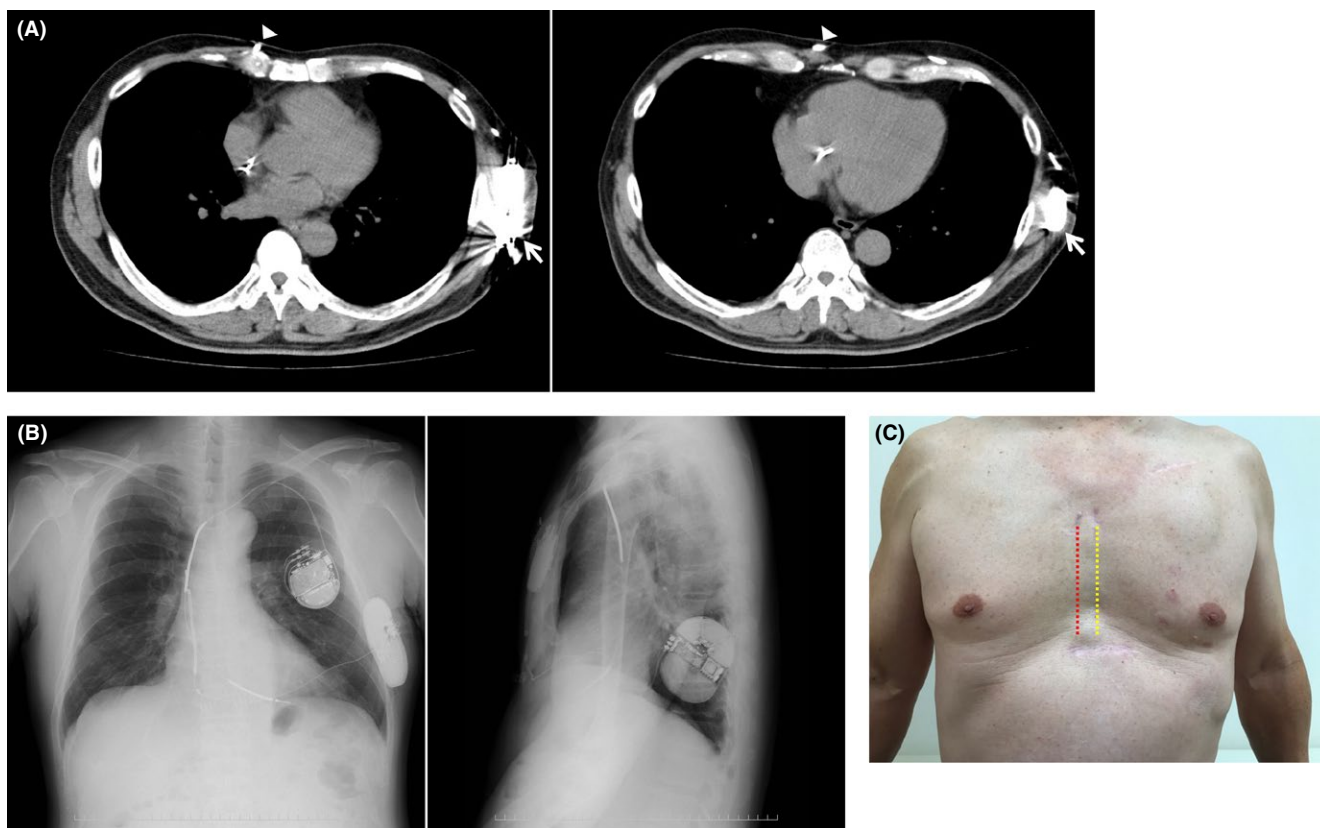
Images and operative scars after the subcutaneous implantable cardioverter defibrillator implantation. A, Computed tomography. Arrows indicate the generator inserted between the serratus anterior muscle and latissimus dorsi muscle. Arrowheads indicate the lead positioned along the right sternal border. B, Posterior to anterior and lateral chest X-ray image. C, Operative scars on the chest. The yellow line indicates the first lead position and red indicates the final position
